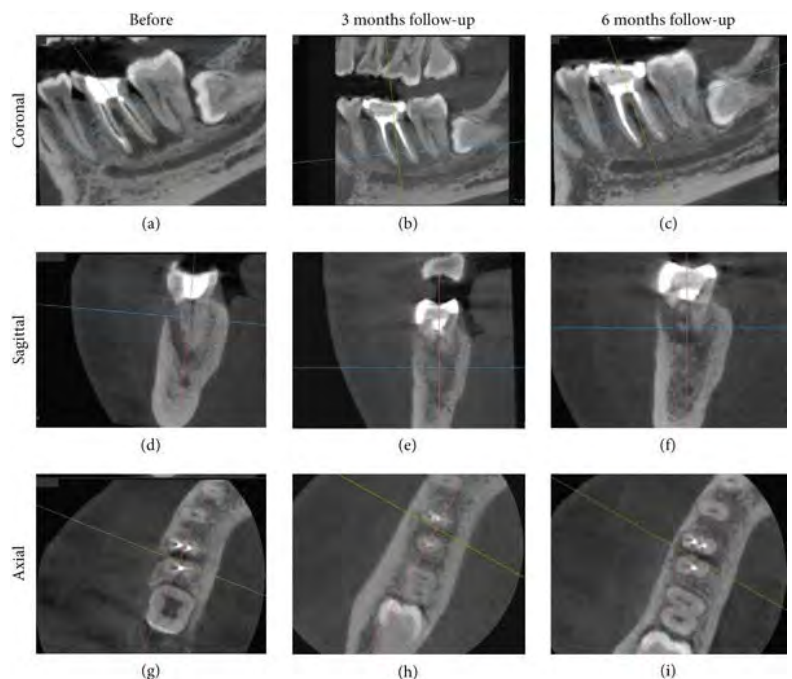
CBCT (a, d, g) before periodontal treatment, (b, e, h) three months, and (c, f, i) six months of follow-up arranged sequentially, consisting of coronal, sagittal, and axial views.
